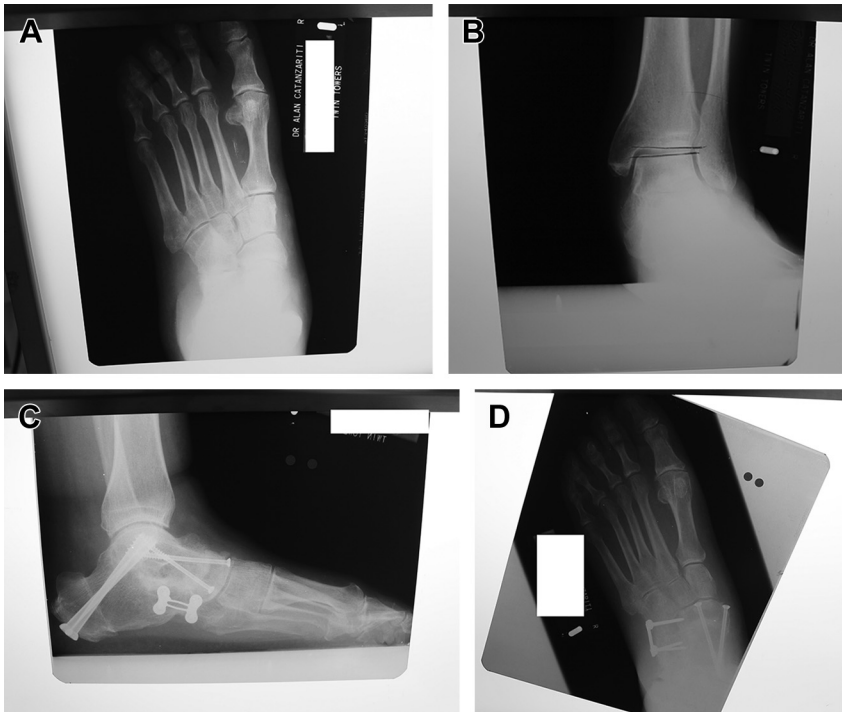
(A) Anteroposterior (AP) radiograph of flatfoot deformity. (B) AP radiograph of the ankle, showing valgus deformity. (C, D) Postoperative radiographs of triple arthrodesis combined with medial displacement osteotomy to address valgus deformity of the ankle.
